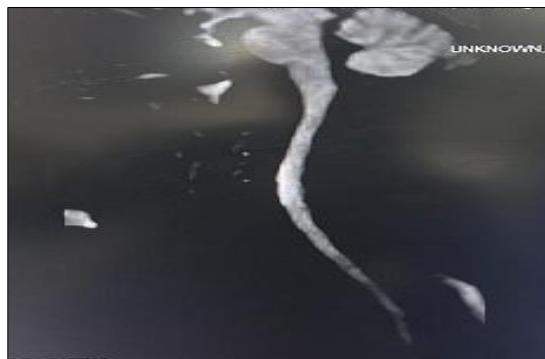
DWI images, well defined restricted diffusivity seen in the ventral cervical cord parenchyma.
